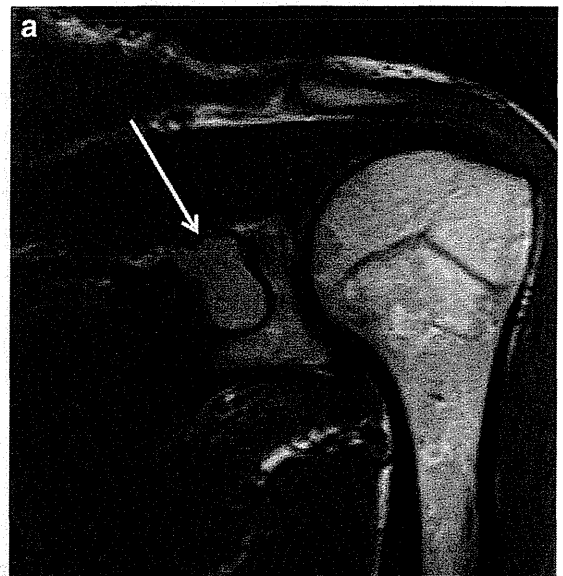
Retiform hemangioendothelioma in a 42-year-old woman who presented with left shoulder pain. She had undergone several surgical operations for local recurrence from childhood. a Coronal T1-weighted MR image shows a slight, ill-defined mass near the suprascapular notch, hyperintense to muscle (*arrow*). b Axial fat-saturated T2-weighted MR image shows intermediate intensity to muscle (*arrow*). c Coronal contrast-enhanced T1-weighted MR image shows a heterogeneous, ill-defined mass with proliferation of vascular channels of peripheral area (*arrows*)
